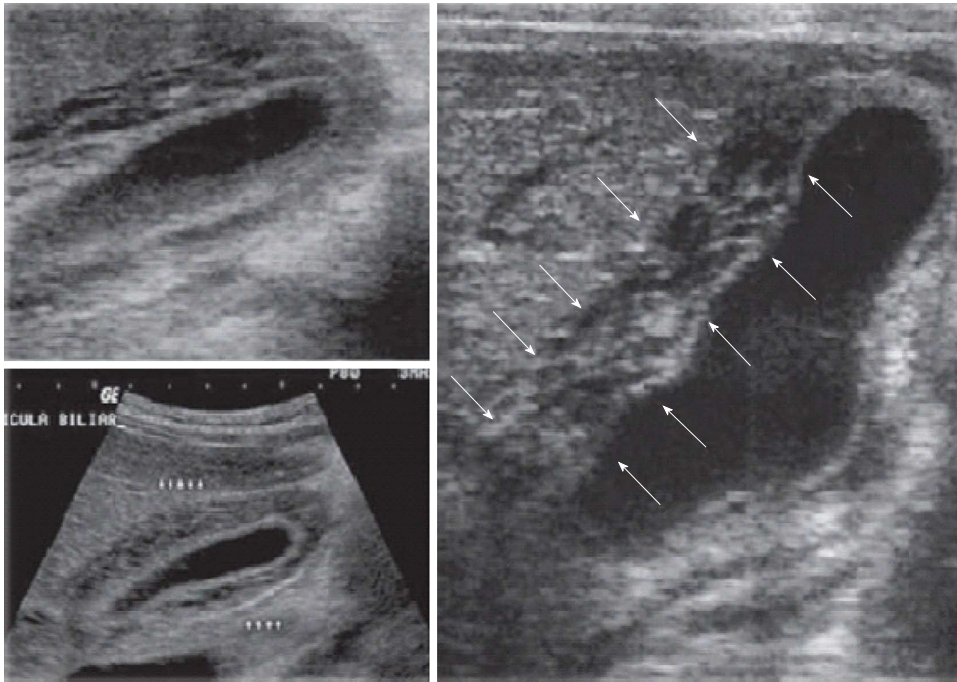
Transabdominal ultrasound in acute cholecystitis.
